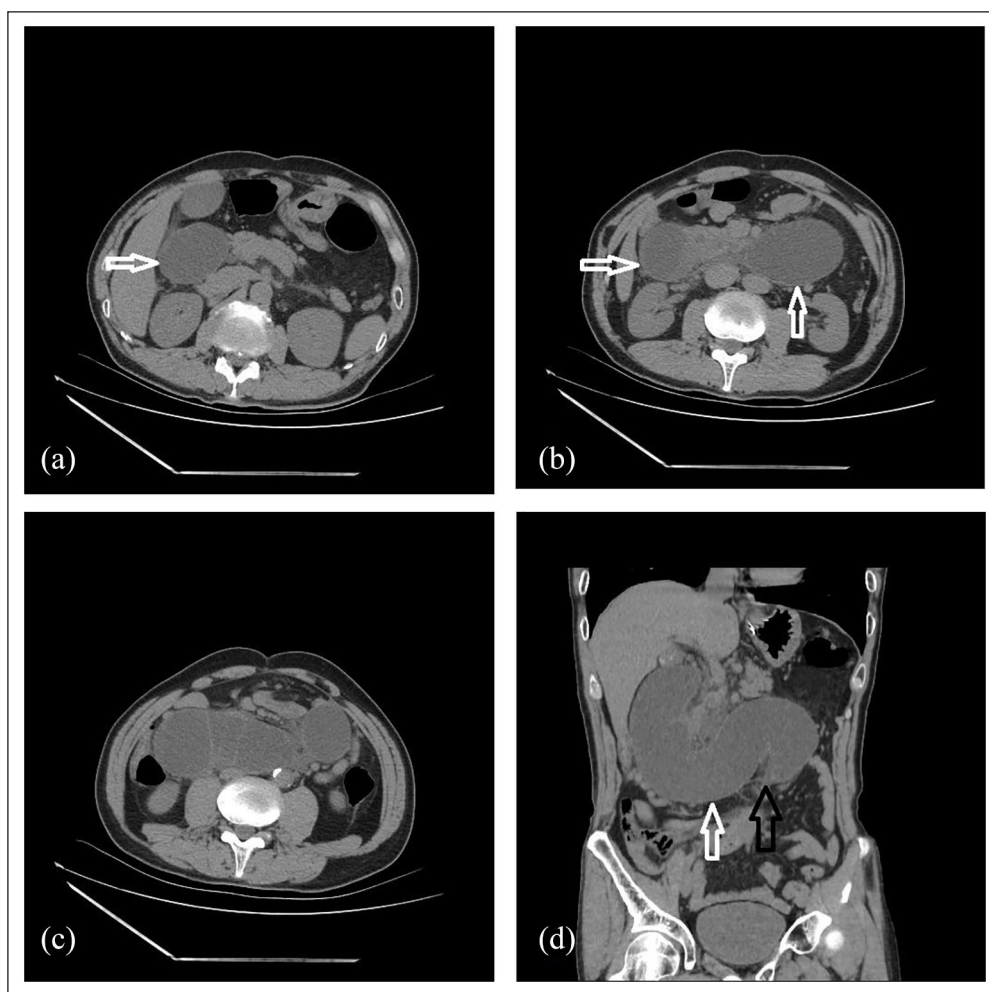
Plain CT scans of the whole abdomen at the primary healthcare institute. It showed dilatation of duodenum and proximal jejunal loops (white arrow) (a)–(c); duodenal dilation and stenosis above the umbilical level (black arrow) (d). No fluid accumulation was observed in the abdominal cavity.
